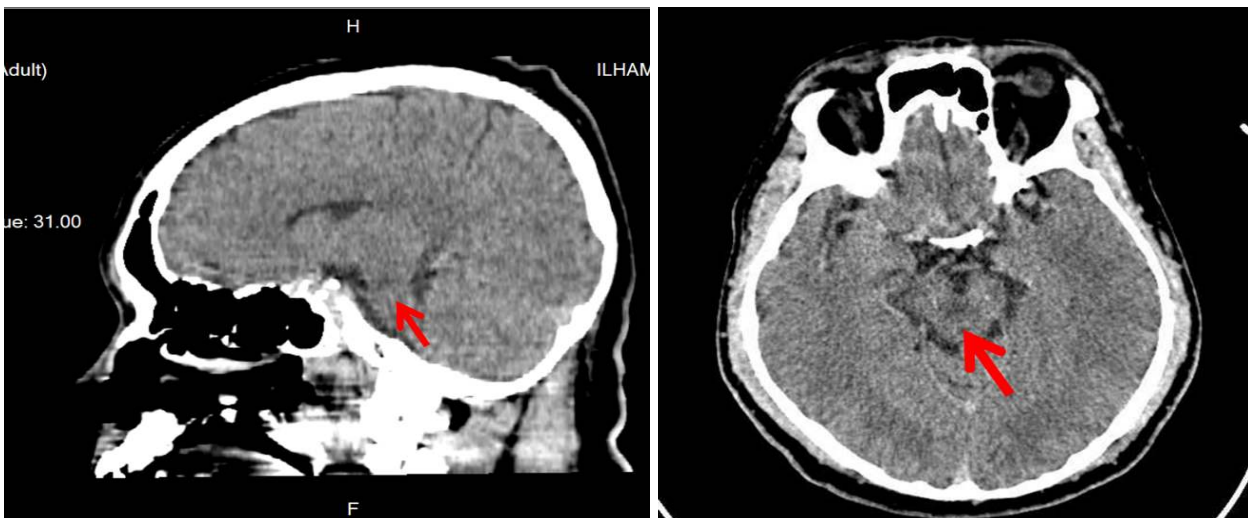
Brain computed tomography (CT) scan without contrast sagittal view (left) dan axial view (right) show hipodensity in brain stem (arrow) due to lacunar infarction in brain stem
